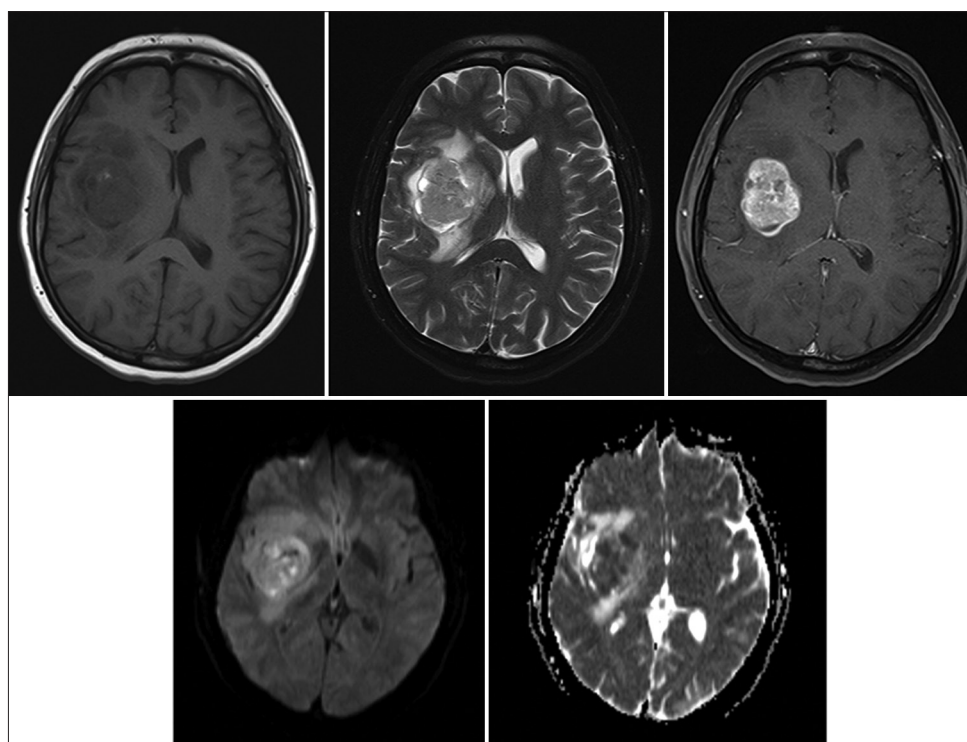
A well-circumscribed tumor that is hypointense in T1-weighted image with heterogeneous texture in T2-weighted image. The lesion was homogeneously enhancing post-gadolinium with restricted diffusion
